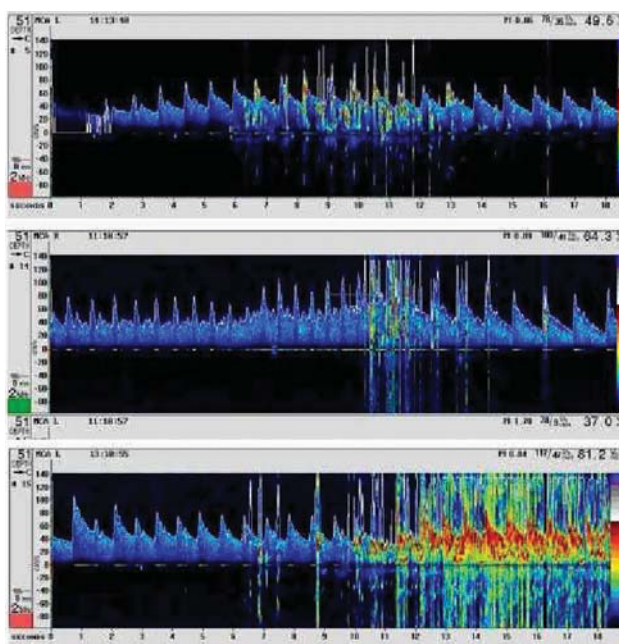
Diagnosis of patent foramen ovale by Doppler study of the middle cerebral artery. Top: pattern suggesting more than a slight degree of shunting. Center: shower pattern. Bottom: curtain pattern.
